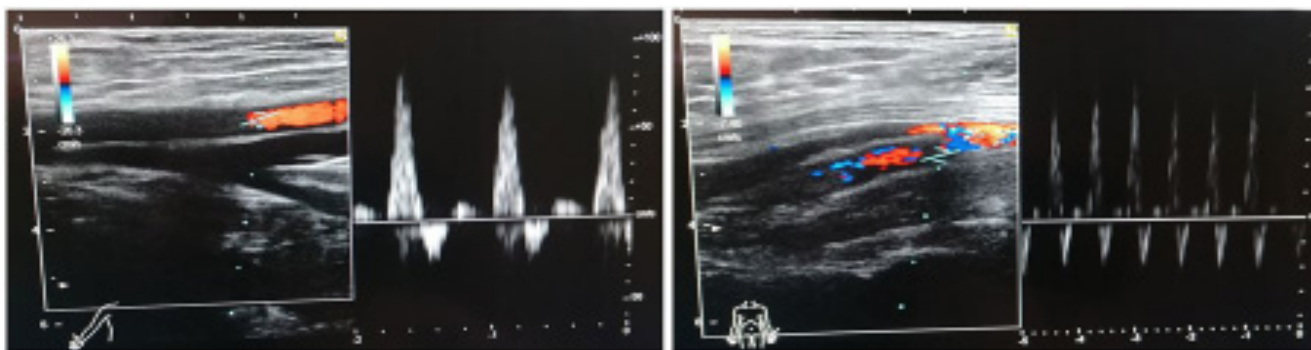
Doppler ultrasonographic examination in the follow-up of patients in the VCD group (Femoral (A) and popliteal artery (B) flow is normal, vessel walls are smooth, and there is no occlusion in the vessel diameter).
